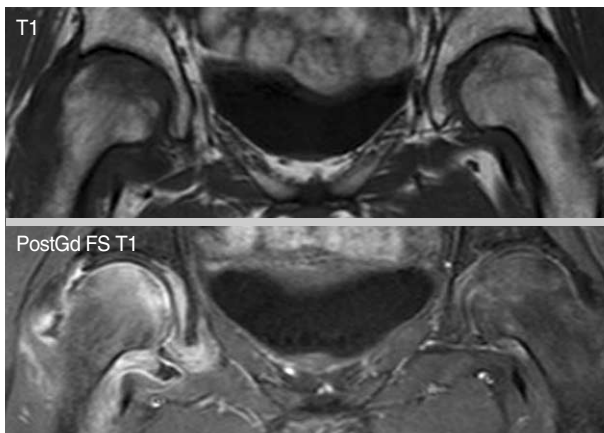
On MR images taken at 7 weeks postpartum, the bone marrow edema in the left proximal femur had decreased markedly, whereas bone marrow edema persists in the right proximal femur. At this time, left hip pain had almost completely disappeared.
